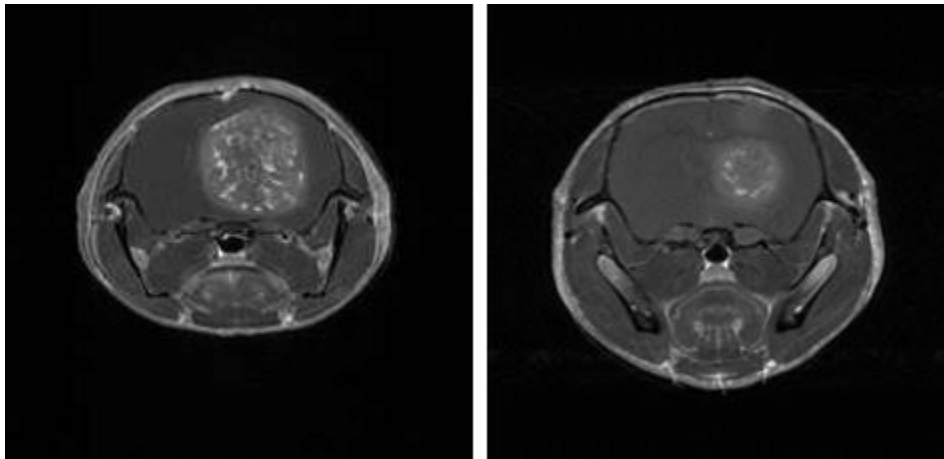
T1-weighted MRI-scans with contrast medium on day 29 p.o., showing an untreated pLXSN-tumor on the left and an untreated EphB4^{OE}-tumor on the right. Untreated pLXSN-tumors displayed clearly bigger tumor volumes than untreated EphB4^{OE}-tumors.
